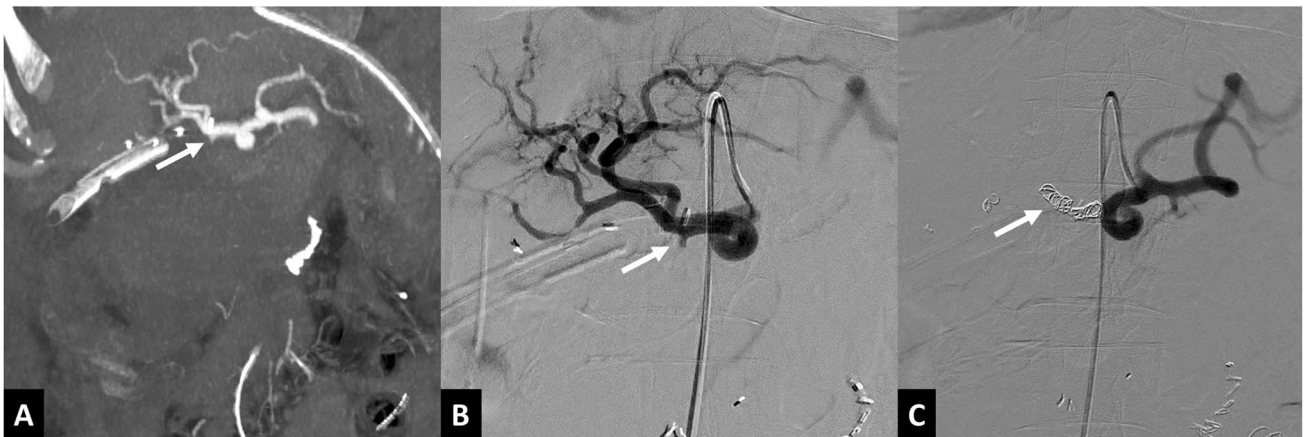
Seventy-year-old male who underwent pancreatoduodenectomy for periampullary carcinoma, came with bleeding from drainage catheter three days after the surgery. A Coronal computed tomography (CT) angiography image shows a small pseudoaneurysm at the level of gastroduodenal artery stump (arrow). B Digital subtraction
